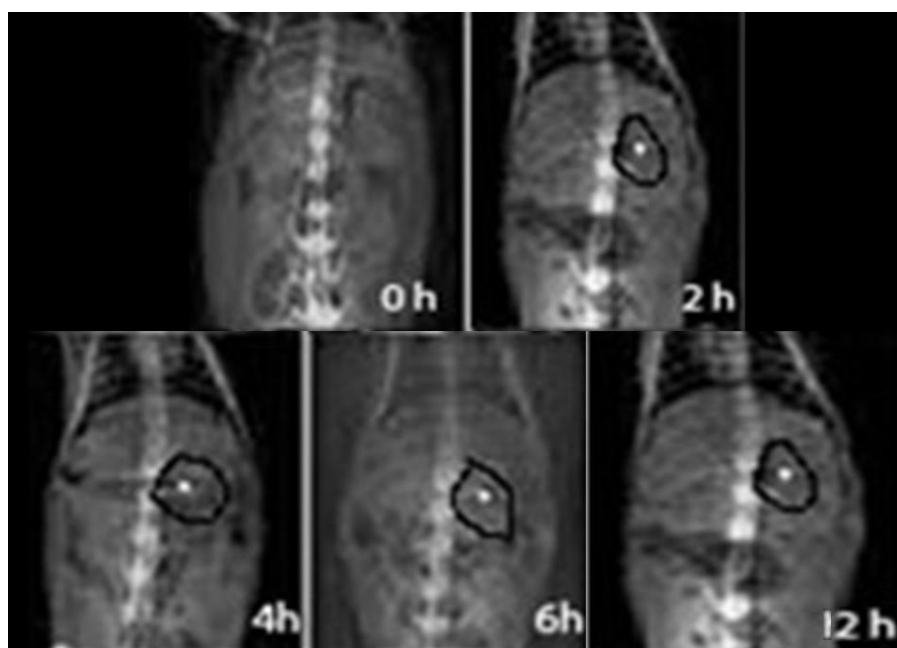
X-ray photographs of the BaSO₄-loaded Levofloxacin floating tablets (F12) in the stomach at (a) 0h, (b) 2h, (c) 4h, (d) 6h, and (e) 12h
